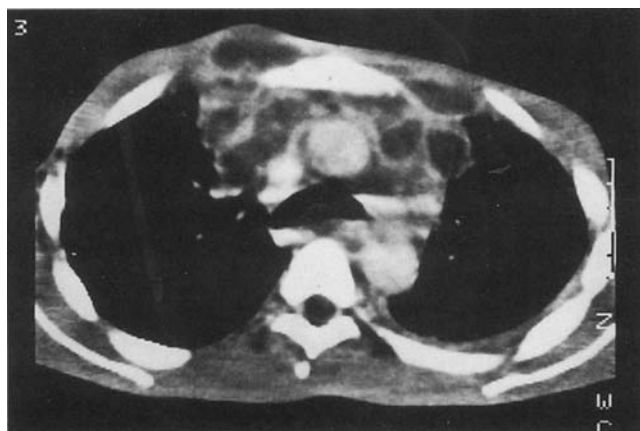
CT scan of the chest of a patient with disseminated *Mycobacterium scrofulaceum* infection shows confluent lymphadenopathy with prominent necrosis in the anterior mediastinum. Invasion of the contiguous chest wall with subcutaneous abscess formation was also apparent.
